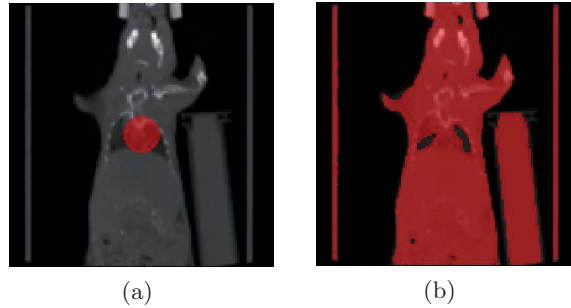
The evolution from (a) the initial region to (b) the *target region* closely enclosing the lungs in the perfusion CT data.
